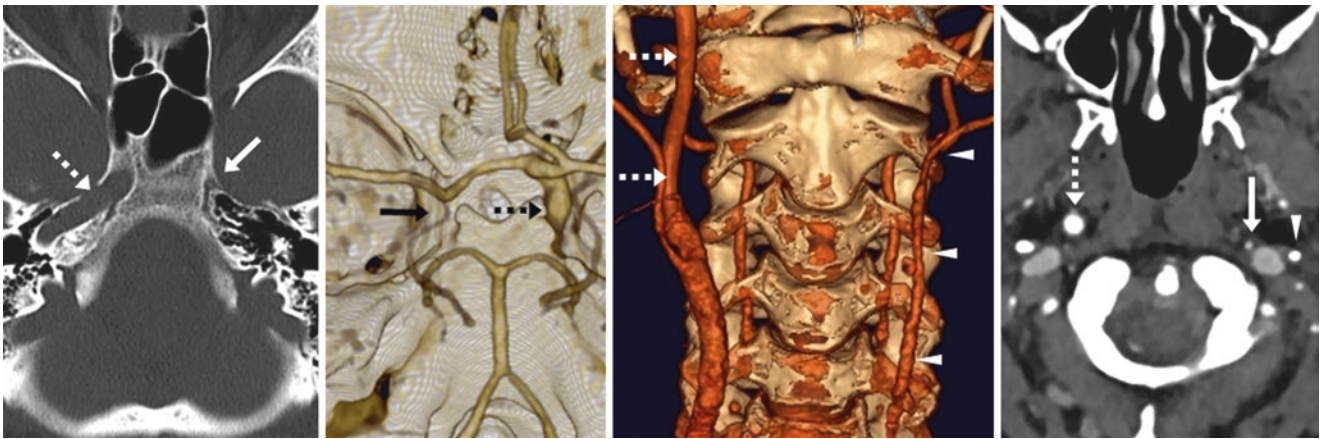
A 39-year-old had a tiny, hypoplastic left ICA bony canal (arrows) on nonenhanced CT (left), with an absent left ICA on a CTA with a 3D VR superior head view (left middle), on a cervical AP view (right middle), and on source CTA images (right). The left ECA is patent (arrowheads), and the right ICA (dotted arrows) is normal
